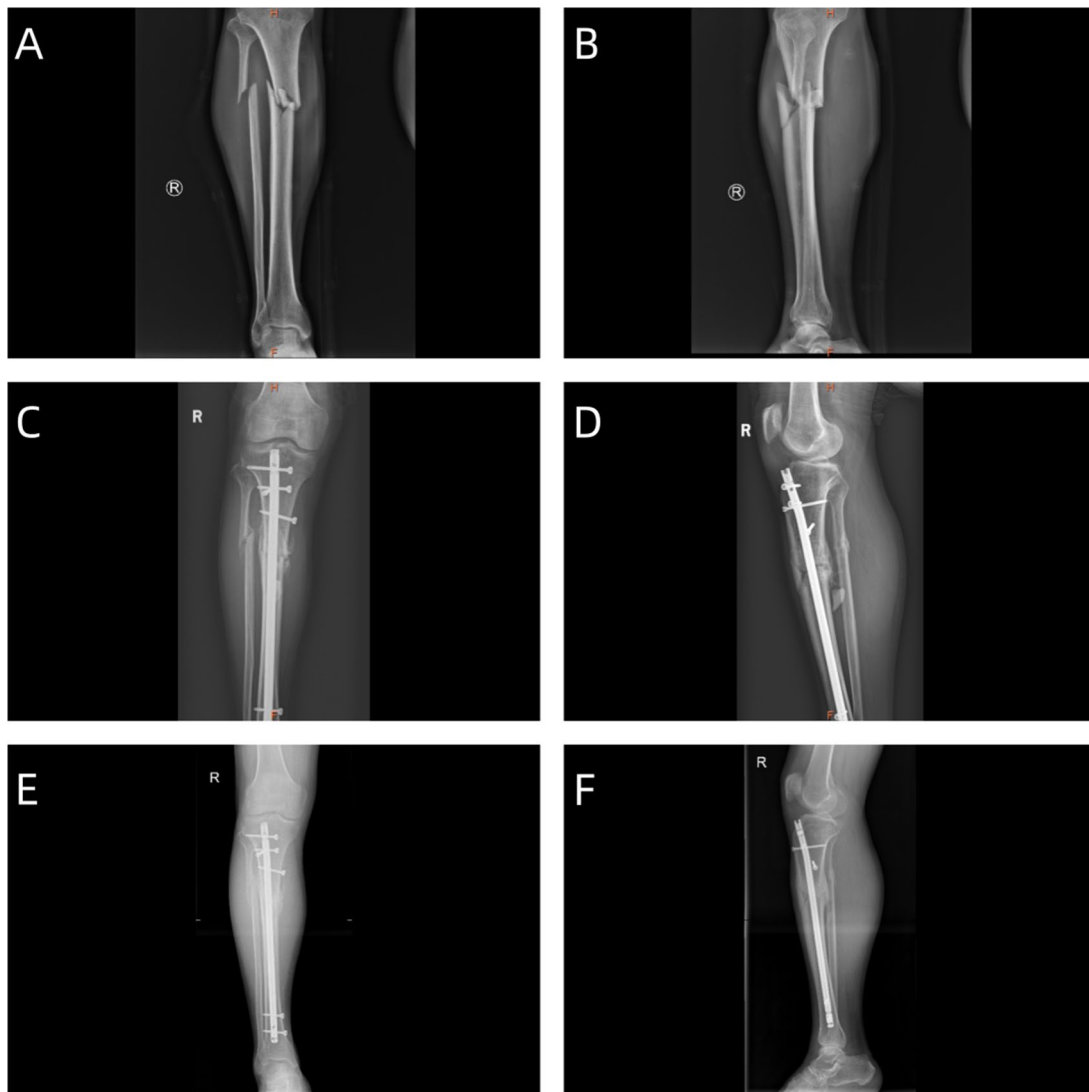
Preoperative and postoperative radiographic data of the patient via the lateral parapatellar approach. (A-B) Preoperative X-rays showing a comminuted fracture of the proximal tibia. (C-D) Follow-up at 3 months postoperatively showing callus formation at the fracture site. (E-F) A one-year postoperative follow-up revealed the disappearance of the fracture lines, indicating complete healing of the fracture
